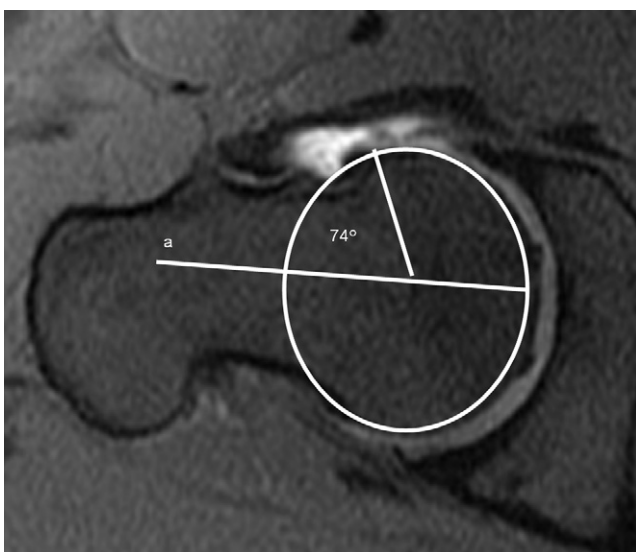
Femoral acetabular impingement. Axial oblique fat-saturation T1-weighted magnetic resonance arthrographic image, showing an abnormal alpha angle. A best-fit circle is drawn, which outlines the femoral head. The angle is calculated as the angle formed between line that bisects the femoral neck (line a) and the point where the femoral head protrudes anterior to the circle.
